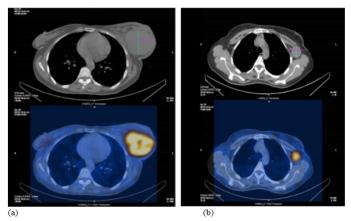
Figure II a,b: SPECT-CT Axial fused and CT slices of the chest and axillae. Demonstrates heterogeneous increased uptake in the large left breast mass and largest left axillary node.
